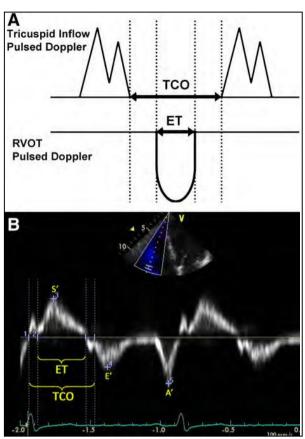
TAPSE (Tricuspid Annuar Plane Systolic Excursion), RVS' (RV Systolic Excursion by Tissue Doppler) and RV MPI (RV Myocardial Performance Index)
